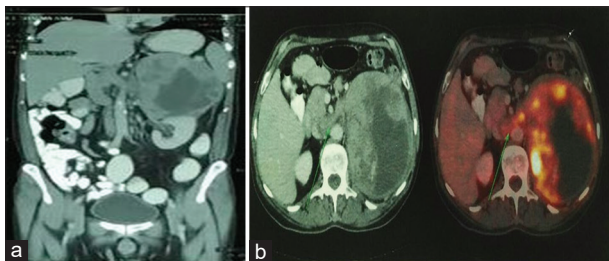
(a and b) CT scan and PET CT shows the mass (13.7 cm × 11.2 × 15.2 cm) originated from the left adrenal gland, displacing the left kidney downwards and the spleen laterally, with multiple enlarged left upper para-aortic lymph nodes largest measuring 1.5 cm × 2.5 cm with tumour thrombosis involving left renal vein and intrahepatic IVC
